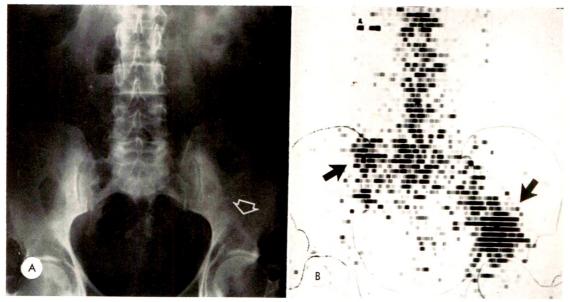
This 55 year old male developed pneumonia and back pain due to collapse of D-5. Carcinoma was suspected but bronchial washings were negative for tumor. (A) Bone survey roentgenogram of pelvis was thought to be normal but (B) Sr<sup>85</sup> scan revealed "hot spots" in left ilium and right sacroiliac joint (arrows). Biopsy of left iliac lesion showed anaplastic carcinoma. In retrospect, the "washed-out" appearance above the left acetabulum (arrow) is a radiolucent metastasis.
